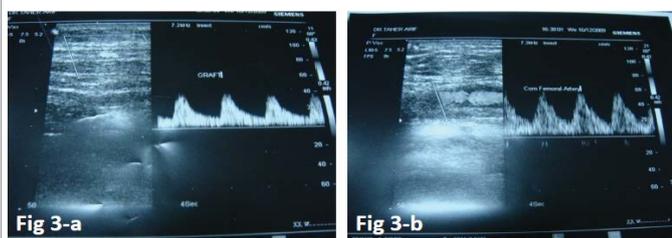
a) Doppler ultrasonography 45 days postoperatively showing a patent graft. b) and a normal flow in common femoral artery.
